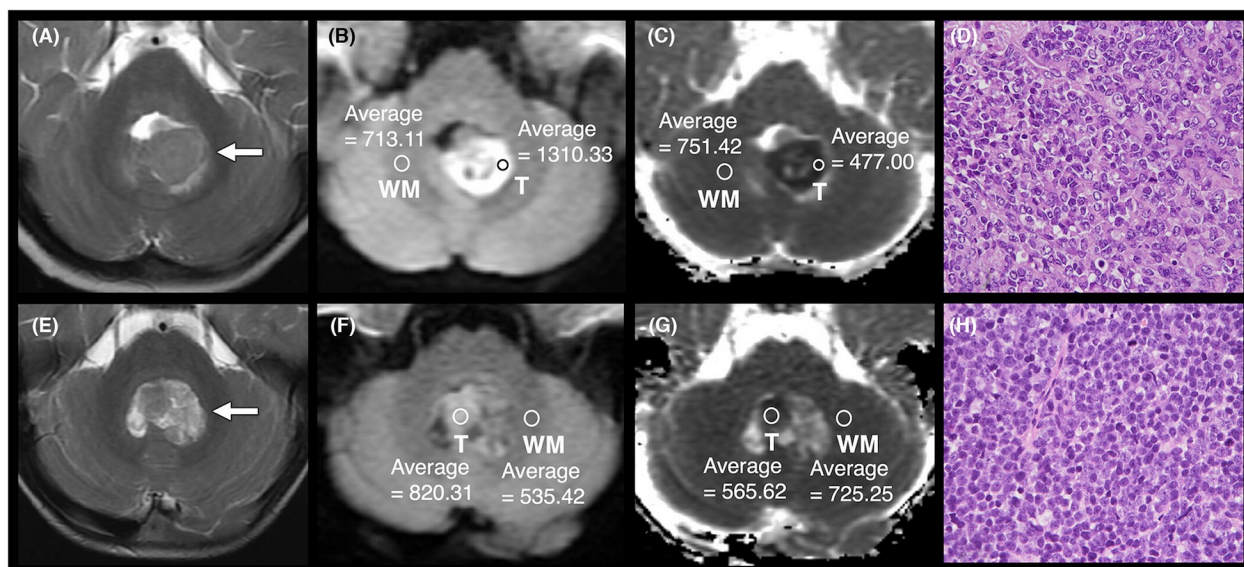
A-D. depict a pediatric patient with AT/RT under a DWI scan. E-H. show a pediatric patient with medulloblastoma under a DWI scan. Both images showed similar imaging features on a T2W scan. AT/RT (A-D) depict tumor cells that had a prominent nucleolus. Medulloblastoma shows tumor cells with small blue round cells.
